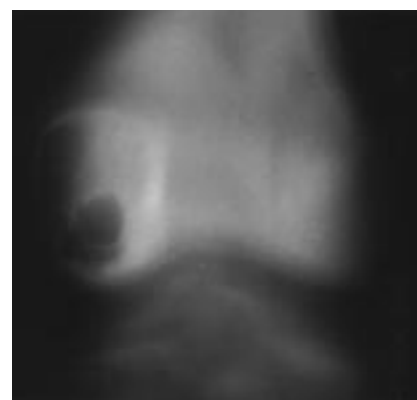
Plain axial tomogram of the distal femur shown in Figure 3. Plain tomography is used less often than it was before CT scans became available, but in some circumstances, especially in lesions adjacent to a curved surface, it is valuable. The relationship of the lesion to the subchondral bone is well seen on this plain tomogram. Coronal CT scans and MR images will also show the lesion, but both are considerably more expensive.
